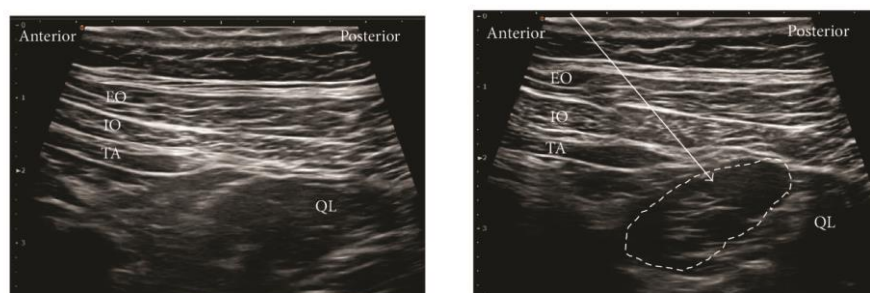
Ultrasound images of lateral QLB. (a) Preinjection and (b) postinjection. EO: external oblique muscle, IO: internal oblique muscle, TA: transversus abdominis, QL: quadratus lumborum, white arrow: needle trajectory, and white dotted line: spread of local anaesthetic.
